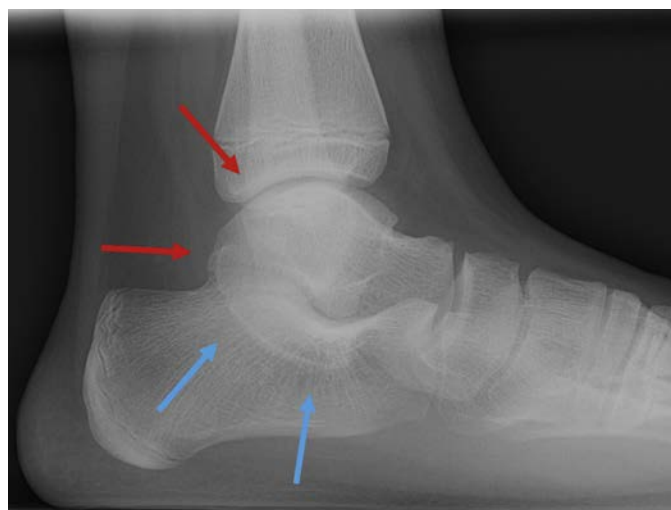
Lateral weight-bearing radiograph of the left ankle in a 14-year-old male baseball player with hindfoot valgus and bilateral talocalcaneal coalitions, demonstrating the “C sign” formed by the posterior border of the sustentaculum tali (blue arrows) and the medial border of the talar dome (red arrows). Symptoms resolved with coalition resection with fat interposition and calcaneal slide osteotomy.
